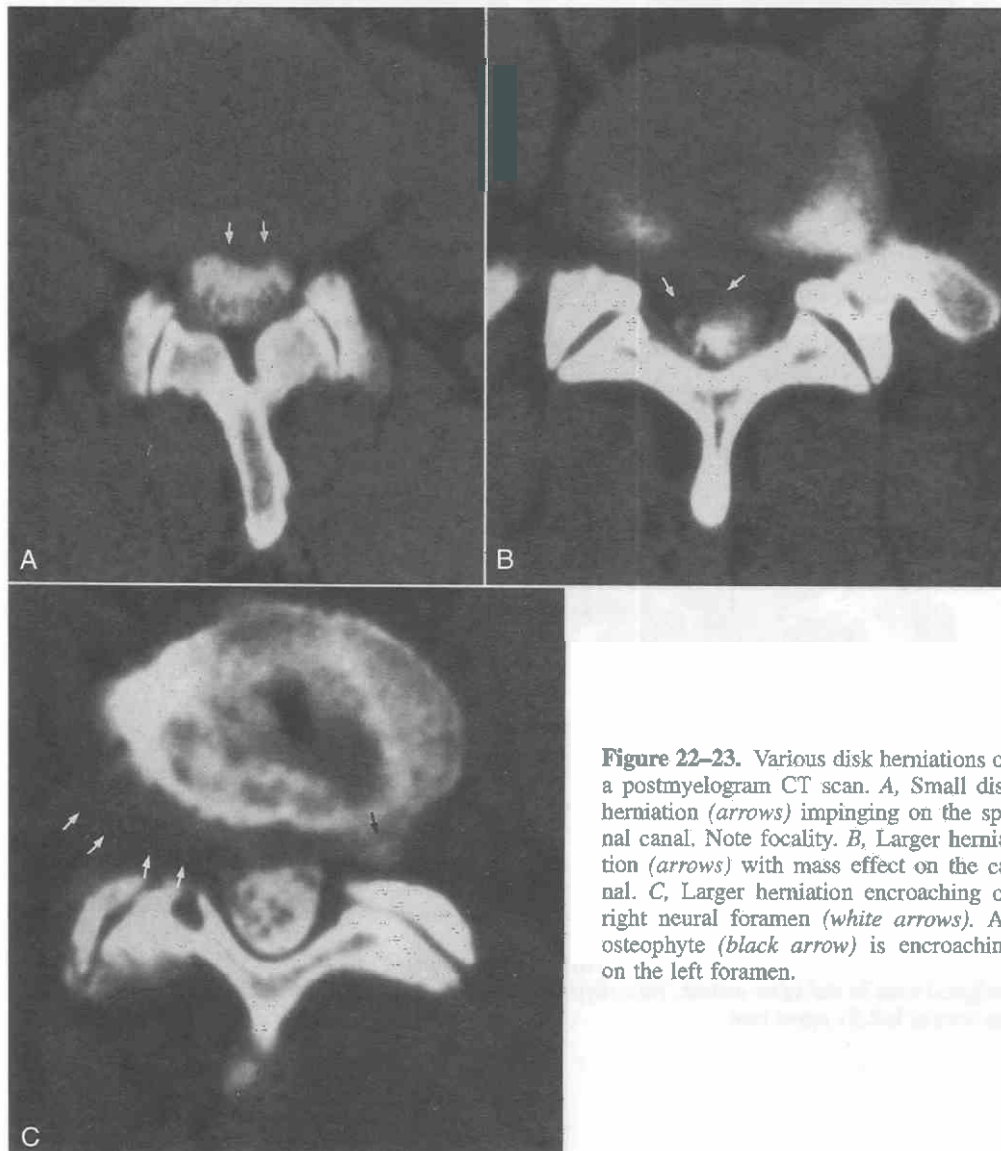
Various disk herniations on a postmyelogram CT scan. A, Small disk herniation (arrows) impinging on the spinal canal. Note focality. B, Larger herniation (arrows) with mass effect on the canal. C, Larger herniation encroaching on right neural foramen (white arrows). An osteophyte (black arrow) is encroaching on the left foramen.
